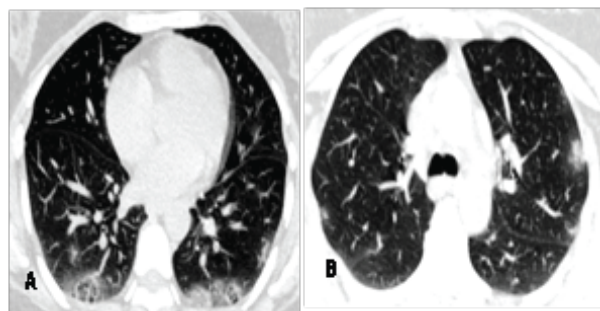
(A and B): Non-contrast axial chest CT images (A,B) in the lung window setting of a 62-year old male COVID-19 positive patient, obtained 9 days after symptom onset, showing bilateral diffuse confluent ground glass opacities with pronounced peripheral and posterior distribution with interlobular septal thickening producing crazy-paving pattern.
